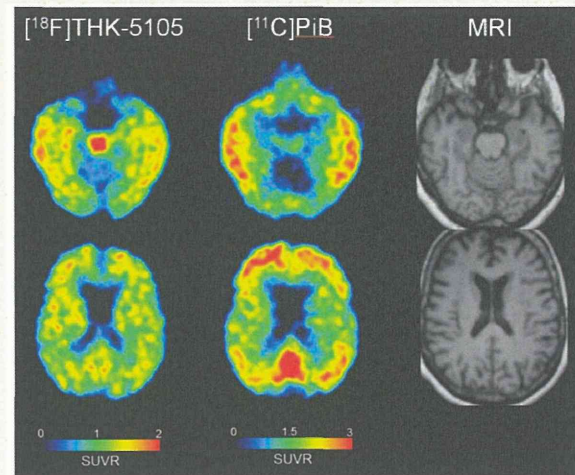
^{18}F -THK5105 PET images from 60–80 min post-injection and ^{11}C -PiB PET images from 40–70 min post-injection in an Alzheimer's disease patient (68-years-old, CDR 1.0, MMSE 20). Co-registered magnetic resonance images are shown on the right.
